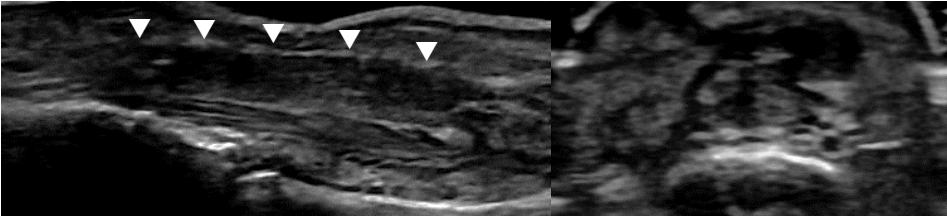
Postoperative ultrasonography images of the nerve conduit at 1 month (A), 2 months (B), and 6 months (C) after surgery. Arrowhead and arrow showing the biodegradable nerve conduit and disappearance of the neuroma respectively.
